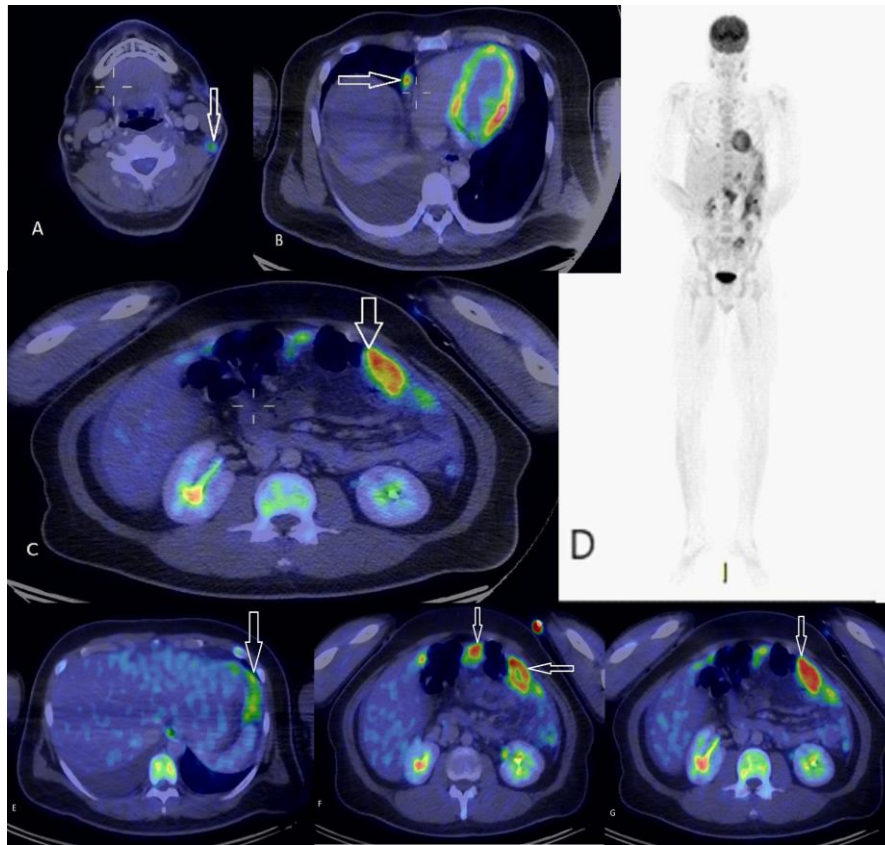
A 30-year-old gentleman with SPTCL involving various sites with the primary disease in the anterior abdominal omentum. Whole-body positron emission tomography/computed tomography.
